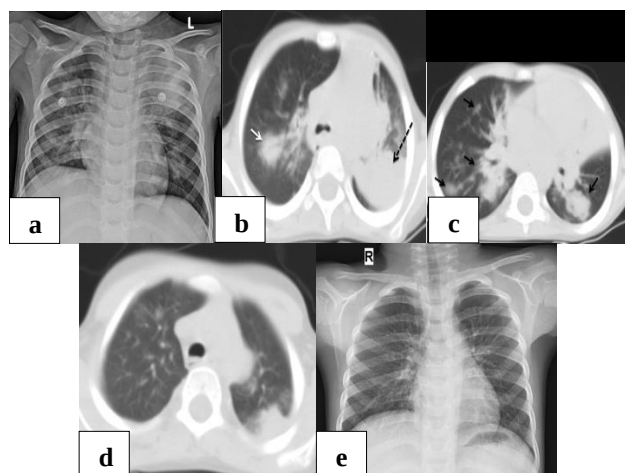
(a) Chest radiograph (AP view) showing patchy air space opacities in both lungs, largest in the left upper zone; (b) and (c) axial section of HRCT lung showing multiple nodules (black arrows) in both lungs with a mass-like lesion in the left upper lobe (dotted arrow); some of the nodules show surrounding halo of ground glass opacity (white arrow); (d) axial section of HRCT lung showing reduction in the size of the left upper lobe opacity (taken after one month of ATT); and (e) chest radiograph (AP view) showing resolution of the lung opacities with normal appearance of the lungs (taken after completion of full course of ATT).
